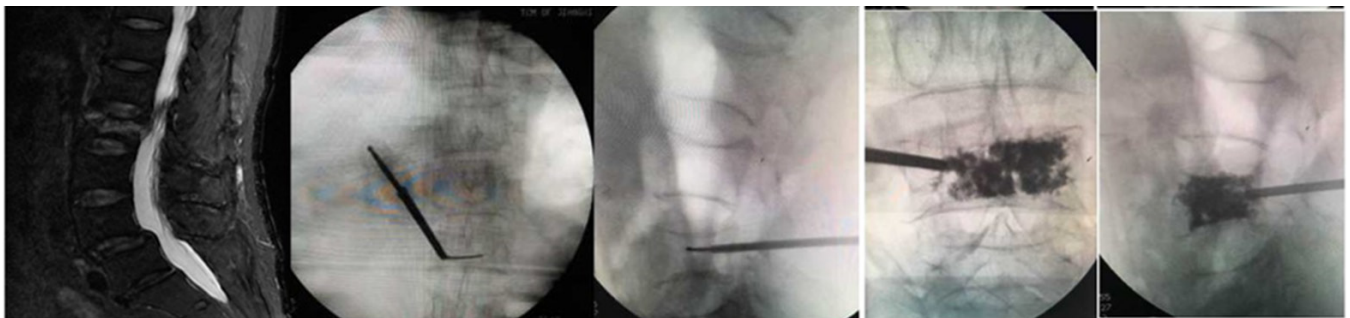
A 77-year-old female patient was admitted to our hospital after rough cough. (A) Preoperative sagittal MRI showed acute fracture of L2 vertebra. (B/C) Plain radiograph showed osteoporotic vertebral compression fracture of L2 vertebra with percutaneous curved kyphoplasty. (D/E) The cement were injected into vertebra body.
